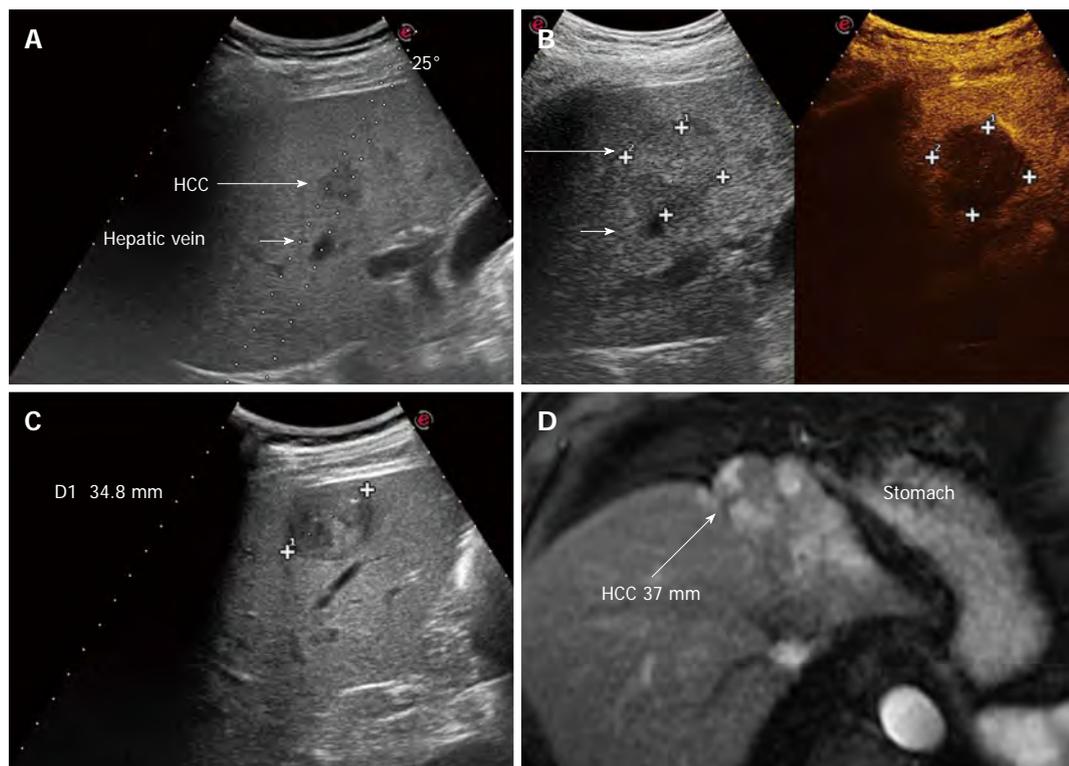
Clinical cases in which performing hepatic resection or radiofrequency ablation had to be decided. A: Ultrasonography through a right inter-costal scan shows a very early hepatocellular carcinoma (HCC) in segment 5 that can be reached with a safe needle track for thermal ablation. Given the small size and easy access, radiofrequency ablation was carried out; B: Post treatment assessment with contrast enhanced ultrasound shows a necrotic devascularized area (34 mm × 35 mm) that includes the tumor with a safety margin > 5 mm; C: Superficial HCC of 35 mm in hepatitis B virus related cirrhosis with preserved liver function. This lesion could be treated by either ablation or resection, but resection is preferable given the superficial location in segment 5 and the size > 3 cm; D: Tumor lesion partially treated by a previous trans-catheter arterial chemoembolization performed in another hospital, in a sub-capsular location close to the stomach. The theoretical path for radiofrequency ablation would lead the needle to puncture the tumor directly and thermal ablation would imply a risk of heat damage to the stomach wall. Laparoscopic resection was the strategy adopted. The long arrow indicates the HCC after treatment.
